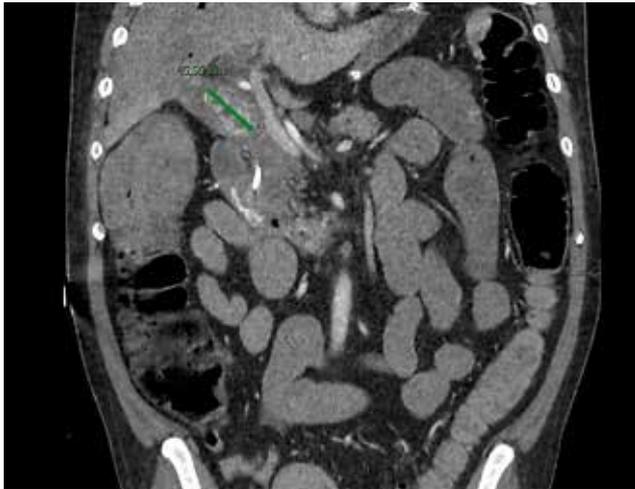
Computed Tomography showing a large, layered gall stone in the gallbladder neck, with compression of the common bile duct.
